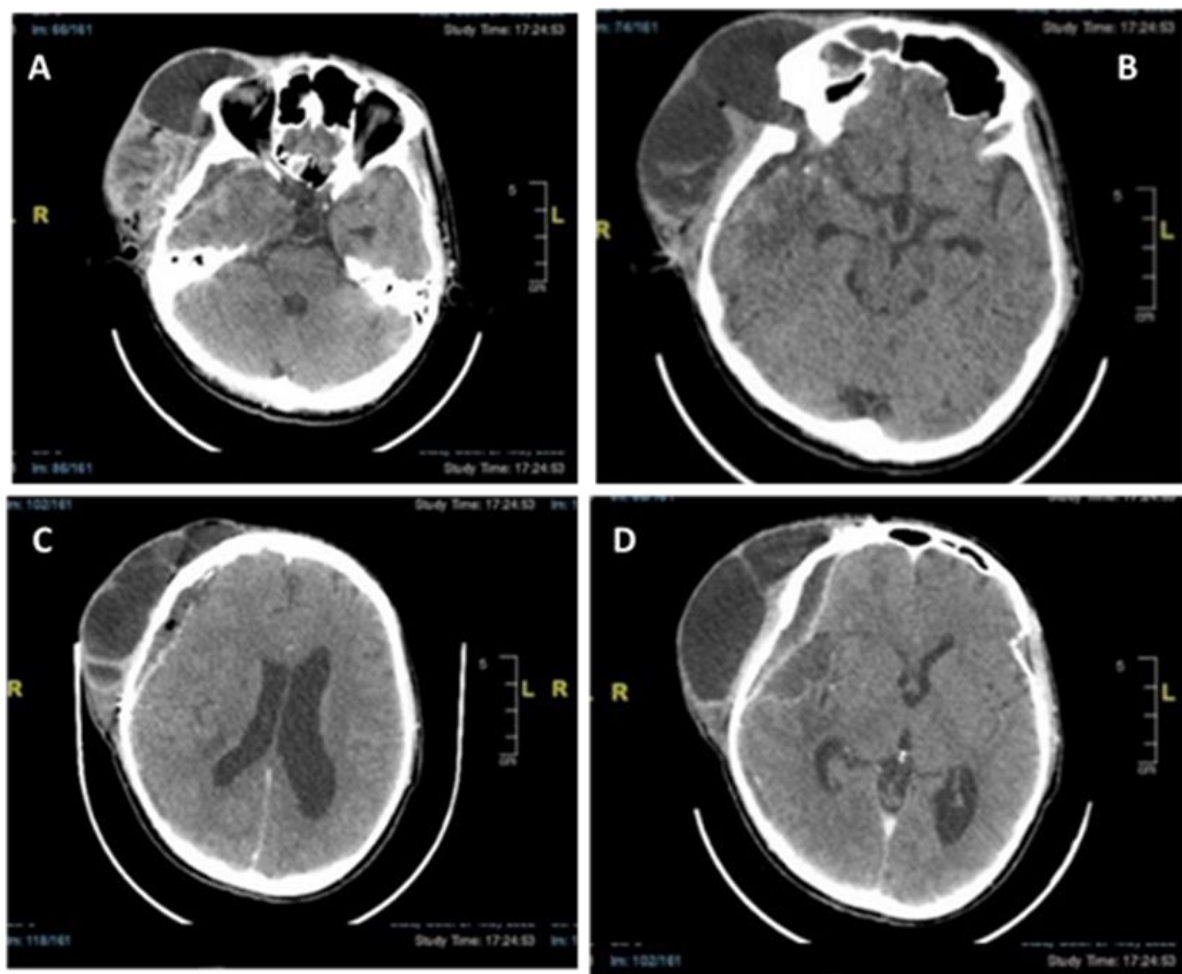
Post-operative contrast head CT scan showing hypodense lesion extracalvaria at right frontotemporoparietal.
